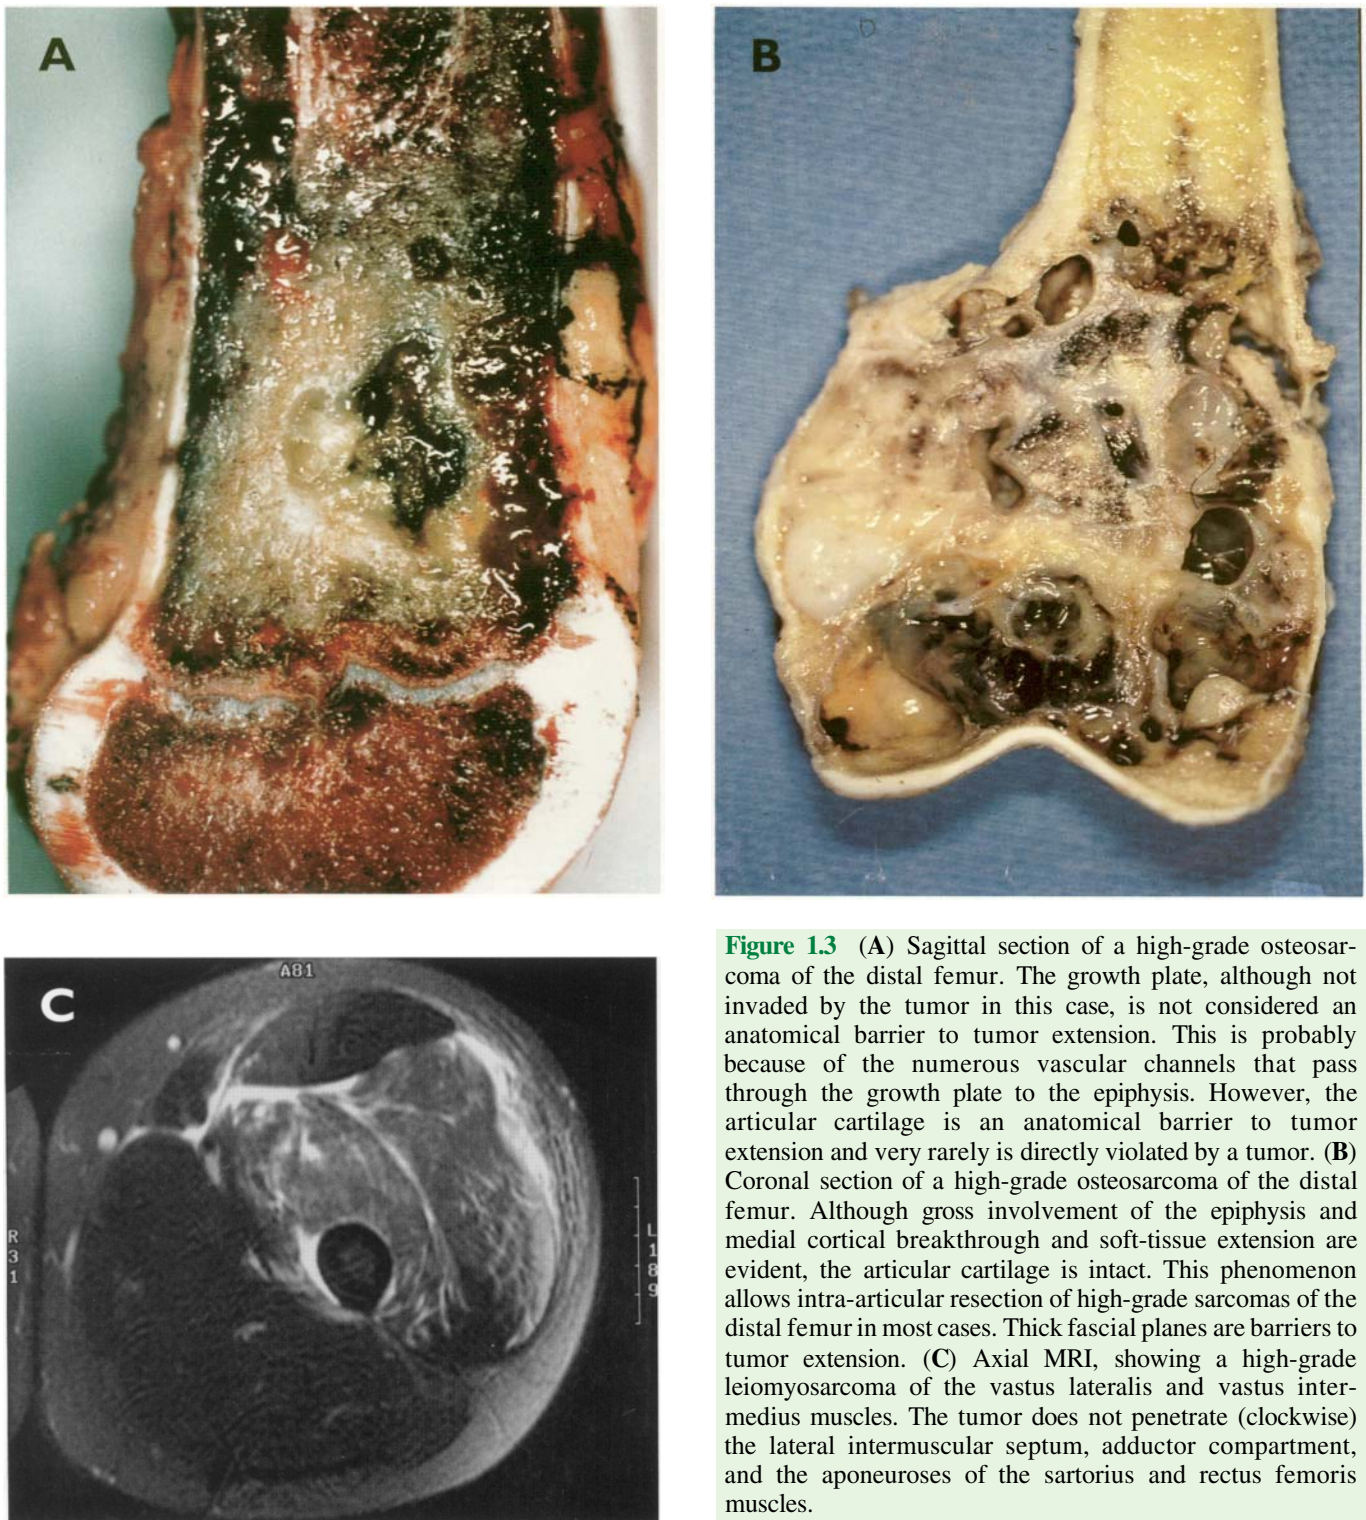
(A) Sagittal section of a high-grade osteosarcoma of the distal femur. The growth plate, although not invaded by the tumor in this case, is not considered an anatomical barrier to tumor extension. This is probably because of the numerous vascular channels that pass through the growth plate to the epiphysis. However, the articular cartilage is an anatomical barrier to tumor extension and very rarely is directly violated by a tumor. (B) Coronal section of a high-grade osteosarcoma of the distal femur. Although gross involvement of the epiphysis and medial cortical breakthrough and soft-tissue extension are evident, the articular cartilage is intact. This phenomenon allows intra-articular resection of high-grade sarcomas of the distal femur in most cases. Thick fascial planes are barriers to tumor extension. (C) Axial MRI, showing a high-grade leiomyosarcoma of the vastus lateralis and vastus intermedius muscles. The tumor does not penetrate (clockwise) the lateral intermuscular septum, adductor compartment, and the aponeuroses of the sartorius and rectus femoris muscles.
